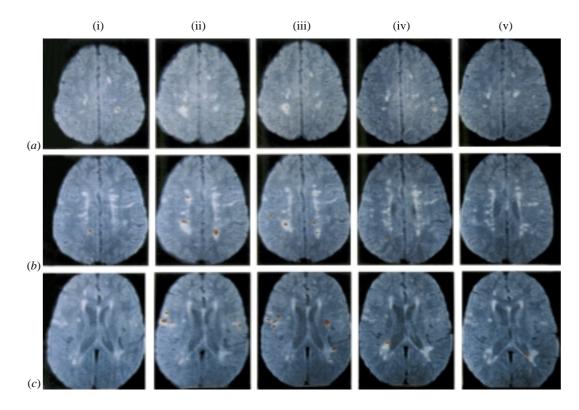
Superimposed serial T2-weighted and gadolinium-DTPA-enhanced T1-weighted MRI scans at monthly intervals in a 24-year-old patient with secondary progressive multiple sclerosis. The areas of enhancement are shown in red (from Miller *et al.* 1997).
